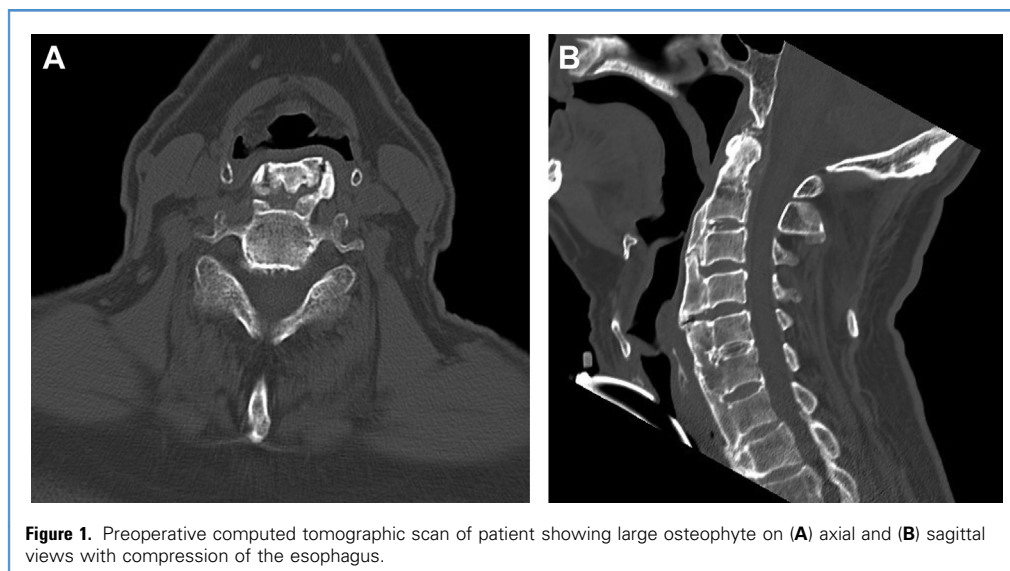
Preoperative computed tomographic scan of patient showing large osteophyte on (A) axial and (B) sagittal views with compression of the esophagus.
